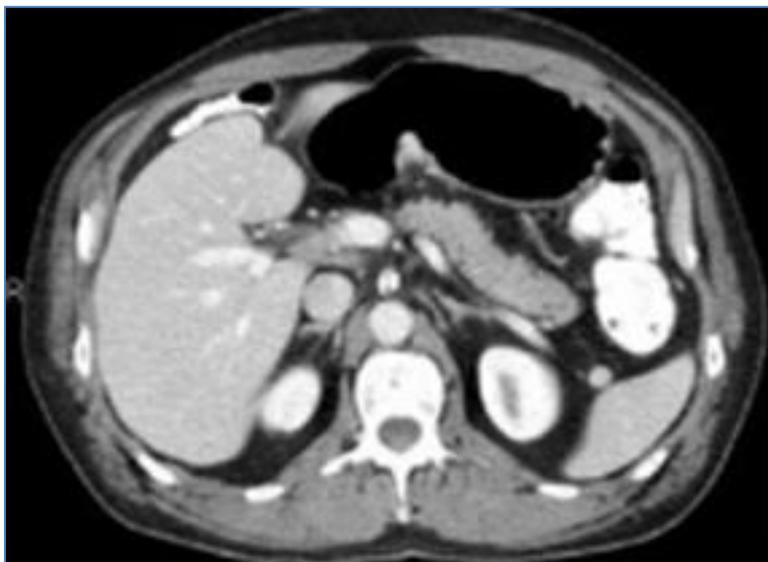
Axial CT scan section showing a localized thickening of the gastric wall.
